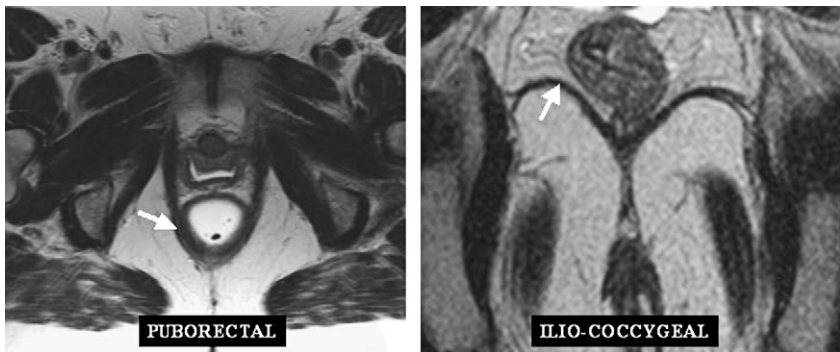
Dynamic MRI defecography. Axial view showing the puborectal muscle (arrow) (left) and coronal view showing the iliococcygeal muscle (arrow) (right).
